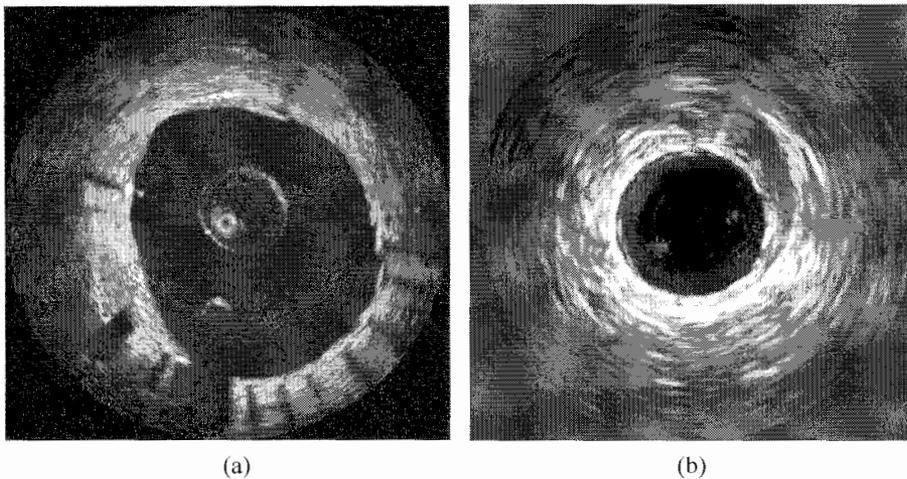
Tacrolimus six months in-stent comparing (a) optical coherence tomography image to (b) intravascular ultrasound image (courtesy of LightLab Imaging).
